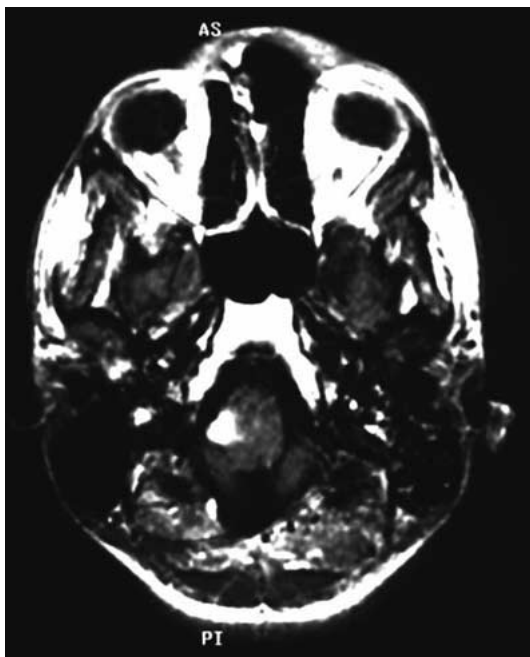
Gadolinium enhanced MRI scan prior to PDT.
